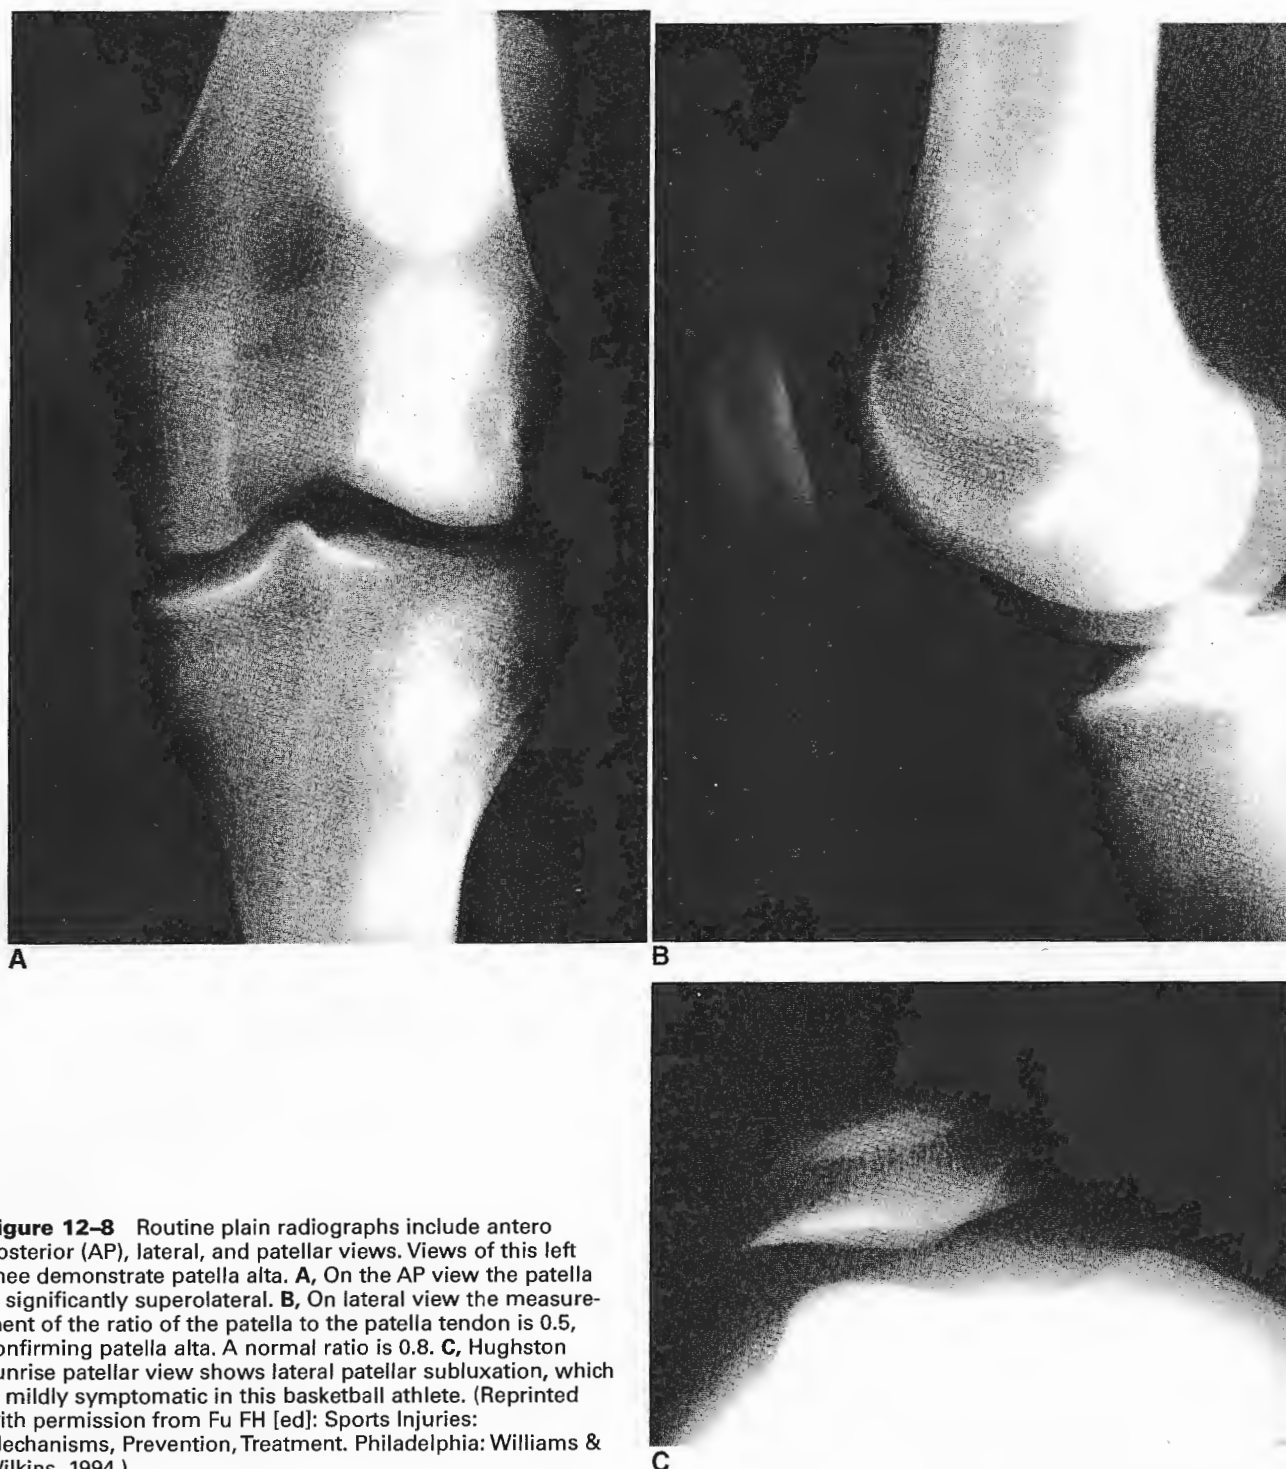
Routine plain radiographs include antero posterior (AP), lateral, and patellar views. Views of this left knee demonstrate patella alta. A, On the AP view the patella is significantly superolateral. B, On lateral view the measurement of the ratio of the patella to the patella tendon is 0.5, confirming patella alta. A normal ratio is 0.8. C, Hughston sunrise patellar view shows lateral patellar subluxation, which is mildly symptomatic in this basketball athlete. (Reprinted with permission from Fu FH [ed]: *Sports Injuries: Mechanisms, Prevention, Treatment*. Philadelphia: Williams & Wilkins, 1994.)
